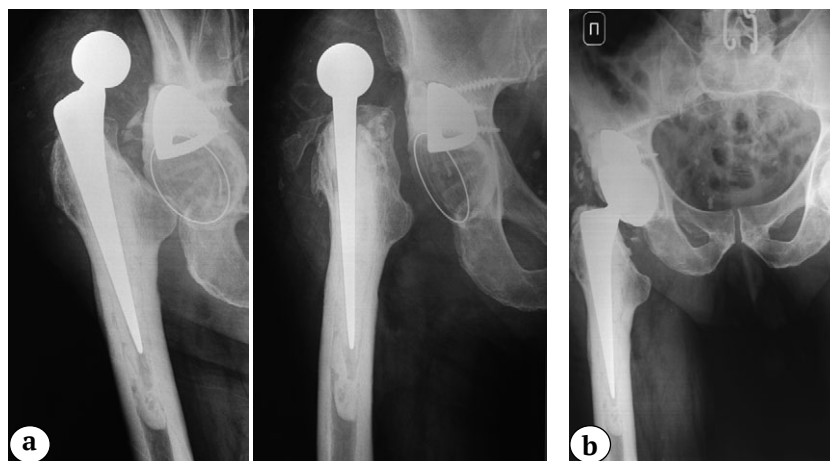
X-rays of the right hip on re-admission:
